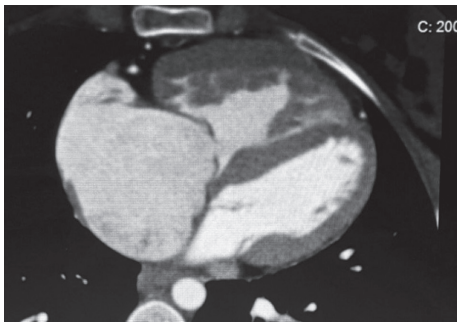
Cardiac four-chamber image on CT. Computed tomography showed hypertrophy in the right ventricular free wall and interventricular septum, and severe dilatation in the right atrium.
